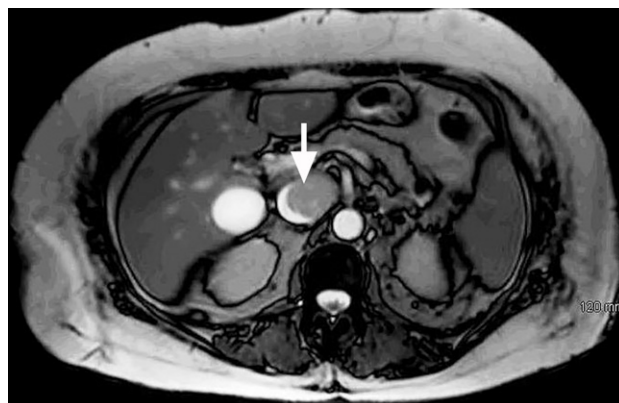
Magnetic resonance image of the abdomen shows the intracaval part (arrow) of the tumor mass.
